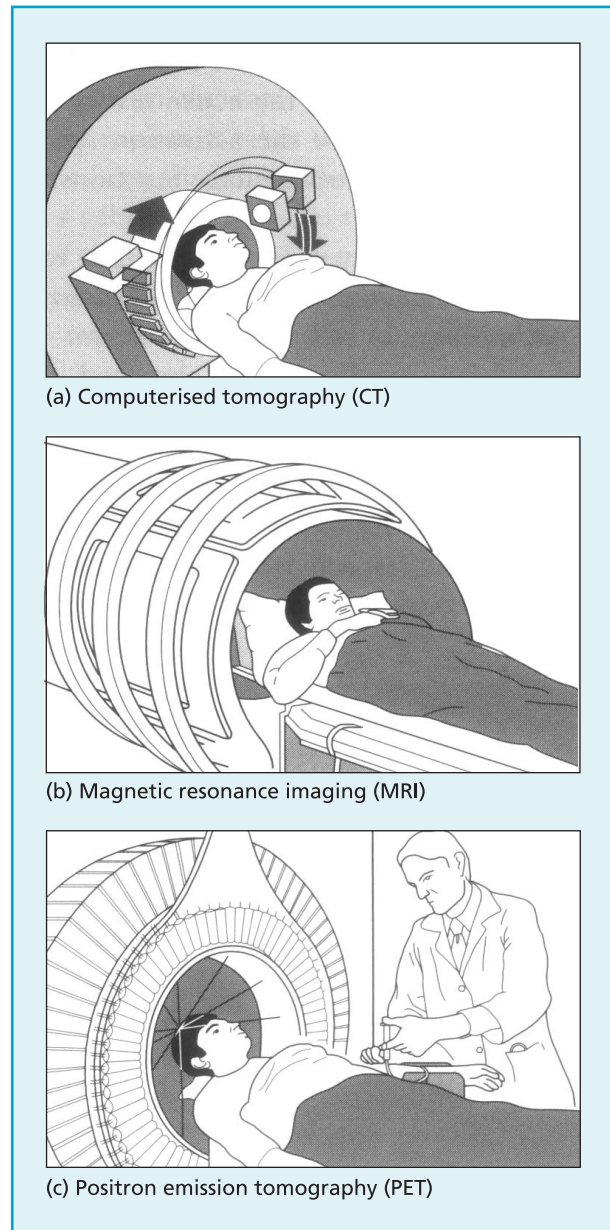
CT, MRI, and PET scanning. CT scans provide reasonably well-defined images of brain structure. PET scans generate images of functional activity, although structure is only poorly defined. MRI can generate "photographic"-quality images of brain structure, and functional MRI (see Figures 2.5 and 2.6) can produce integrated structural and functional images. Source: Rosenzweig et al. (1999). *Biological psychology*. Sunderland, MA: Sinauer Associates Inc. Reproduced by permission of Sinauer Associates Inc.
